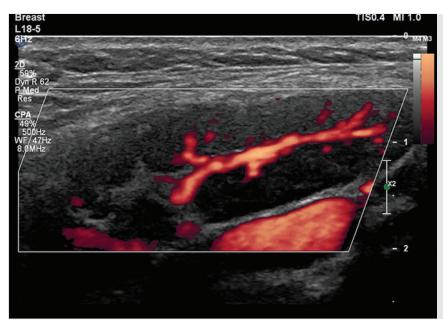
Power Doppler ultrasound image of a benign lymph node showing normal branched hilar flow.
